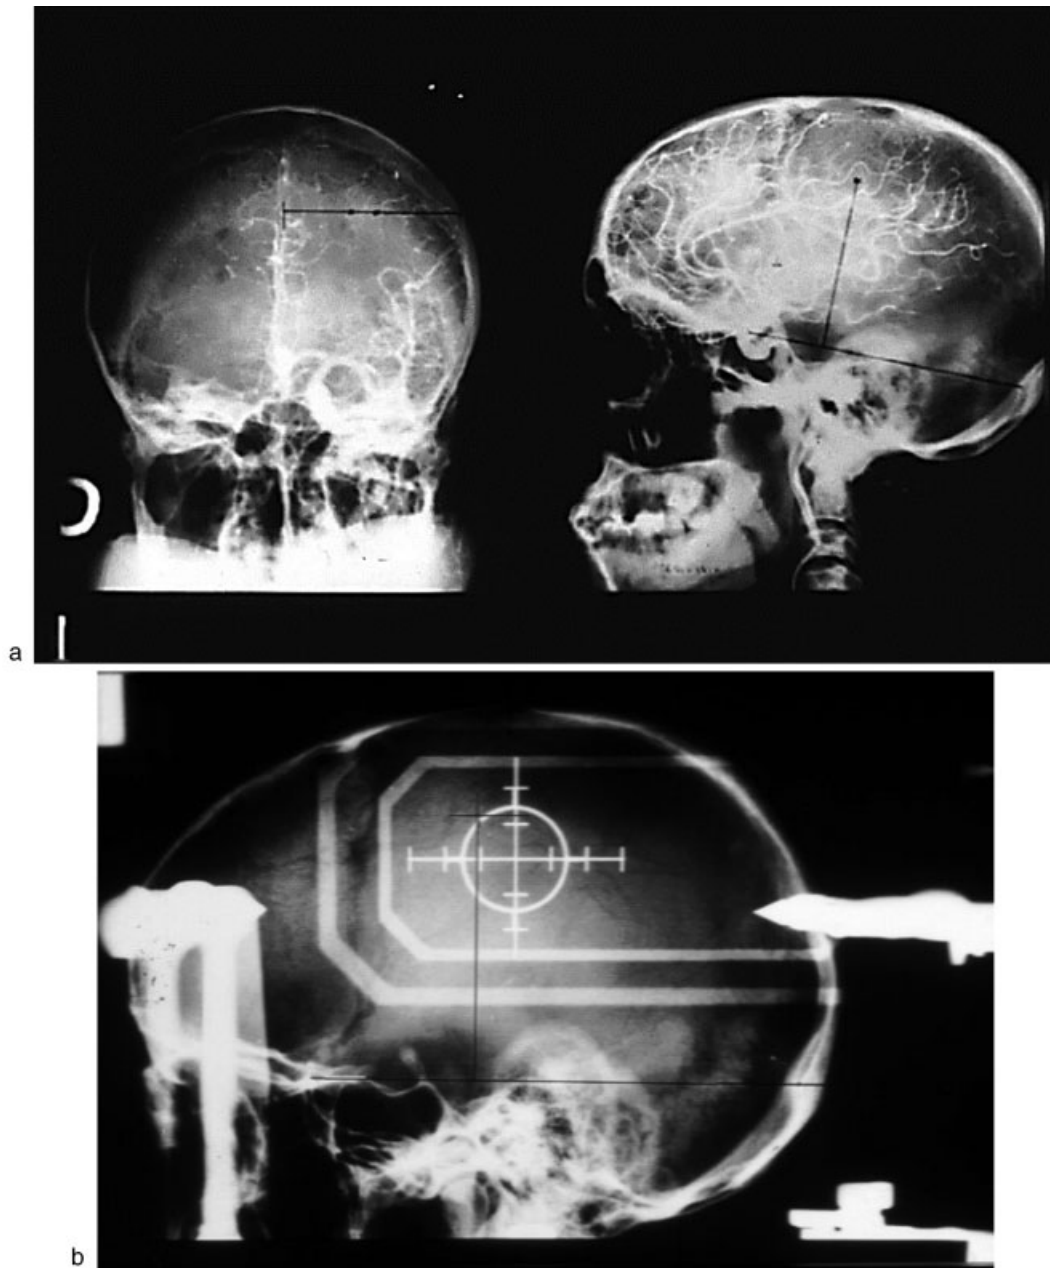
Period 1 (1982–1991) surgical planning. (a) Angiography calculations. (b) Radiography calculations on Todd-Wells stereotactic guide.
